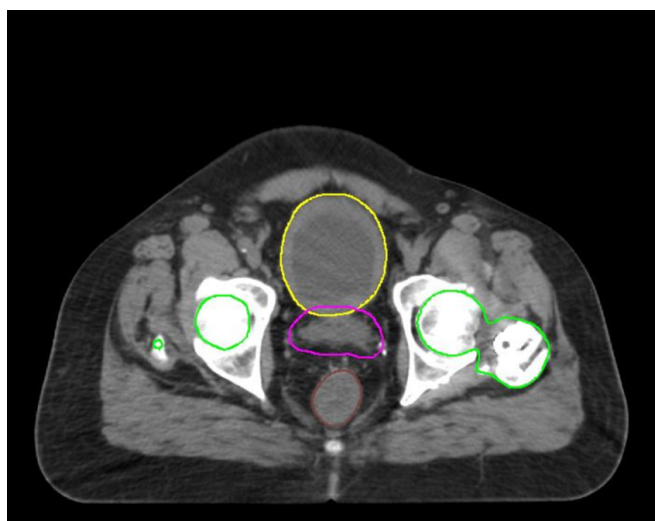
An example slice of a CT image from a prostate cancer patient is shown, with the following anatomical structures delineated: Bladder (yellow), Planning Target Volume (PTV) (magenta), Rectum (brown), Left and Right Femurs (green). From [56]
